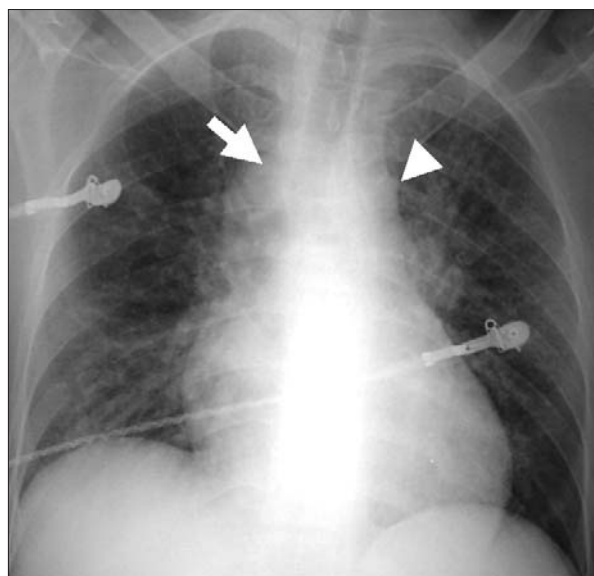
Posteroanterior chest-X-ray: minimal superior mediastinal widening with dilatation of the azygos vein (arrow) and a prominent aortic nipple (arrow head) representing a dilated superior left intercostal vein suggestive of collateral venous flow. Mild cardiac enlargement is noted. Interstitial opacities are seen bilaterally.
